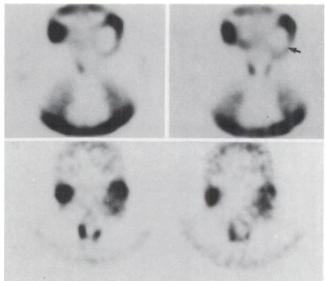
Coronal SPECT images of a patient with a bulky neck node metastasis from a squamous-cell carcinoma of unknown primary site. The HMPAO study (top row) shows decreased perfusion in the lymph node metastasis (arrow) with corresponding IAZA avidity (bottom row). Iodine-123 uptake in the salivary glands is presumably due to partial deiodination (14).
